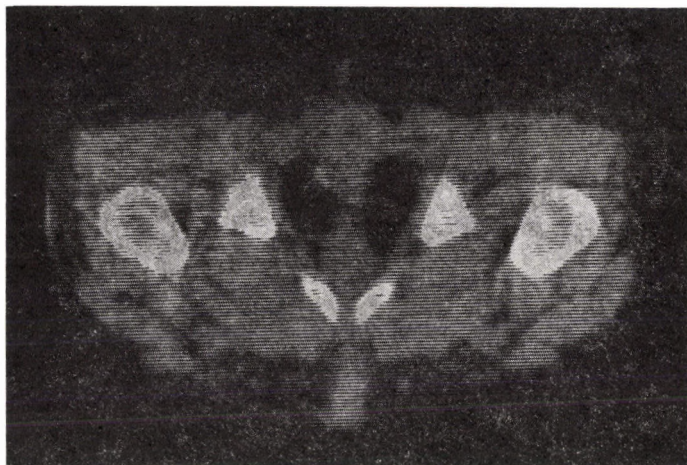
CT scan of a local recurrence in the small pelvis
